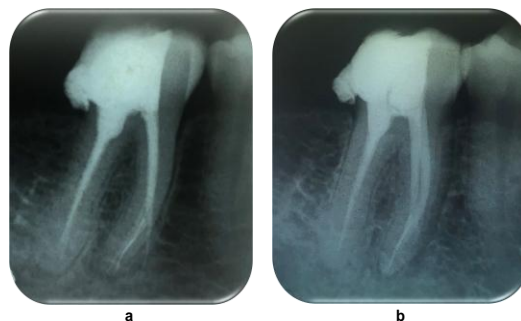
Periapical radiograph of 46 (a), radiograph of 46 after MTA placement and obturation (b)
